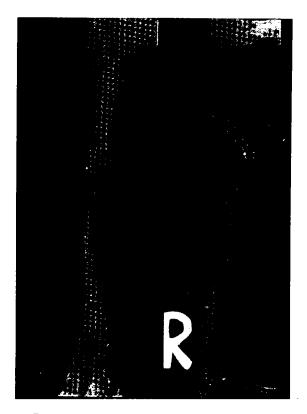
The preoperative anteroposterior and mediolateral radiographic views of case 5 (Type III) Şekil 10. Olgu 5'in preoperatif anteroposterior ve mediolateral radyografik görünümleri (Tip III)
